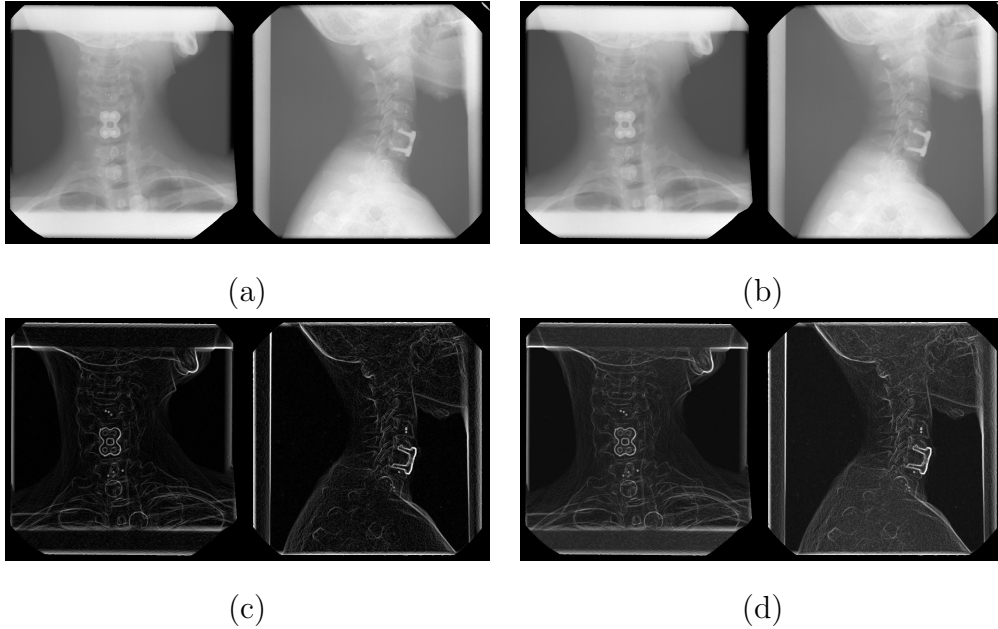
X-ray image processing for both cameras of a random trial. (a) Raw images. (b) Gaussian-filtered images. (c) Gaussian and Sobel filtered images. (d) Gaussian, Sobel and weighted averaged images. Snapshots (c) and (d) have been contrast-enhanced for printing purposes.
